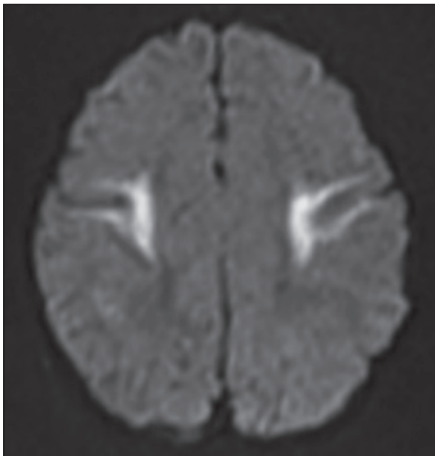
Axial DWI shows restricted diffusion in centrum semiovale
